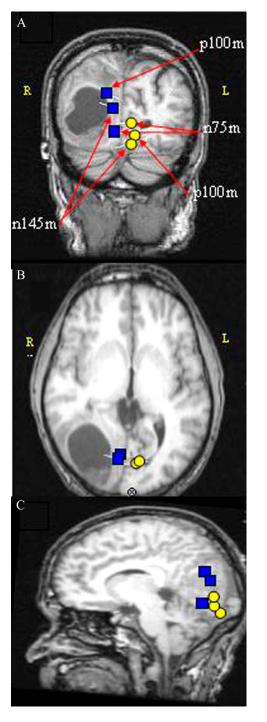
A–C, VEFs in a patient with a right occipital mass. A–C, Patient from Fig. 2 (51-year-old man with a right occipital mass) with VEFs displayed on their structural brain MRI. Left hemifield stimulation is represented by blue squares and right hemifield stimulation is denoted with yellow circles. Coronal slice (A): 1.3 cm; axial slice (B): 4.6 cm; sagittal slice (C): 1.5 cm. These results changed surgical planning from complete resection of tumor, cyst, and margins to tailored resection of the tumor only. Following surgery, his left homonymous hemianopsia improved immediately. VEF, visual evoked fields.
